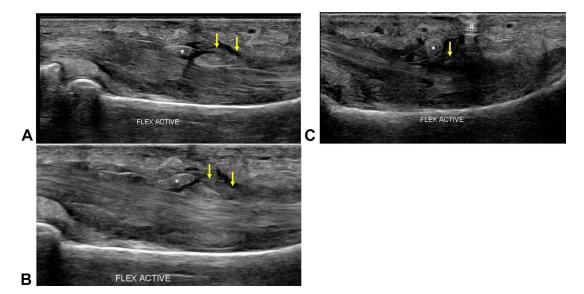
Longitudinal gray-scale ultrasound images of the ring finger volar aspect at the level of the proximal phalanx with the finger A fully extended, B partially flexed, and C flexed to the point of locking. The FDP tendon flap (*, *white outline*) lies flat against the rest of the tendon at rest. With flexion, the flap catches on the intact A2 pulley fibers (*yellow arrows*) and herniates through the laceration defects, becoming thicker and more bulbous in configuration. Air reverberation artifact (#).
